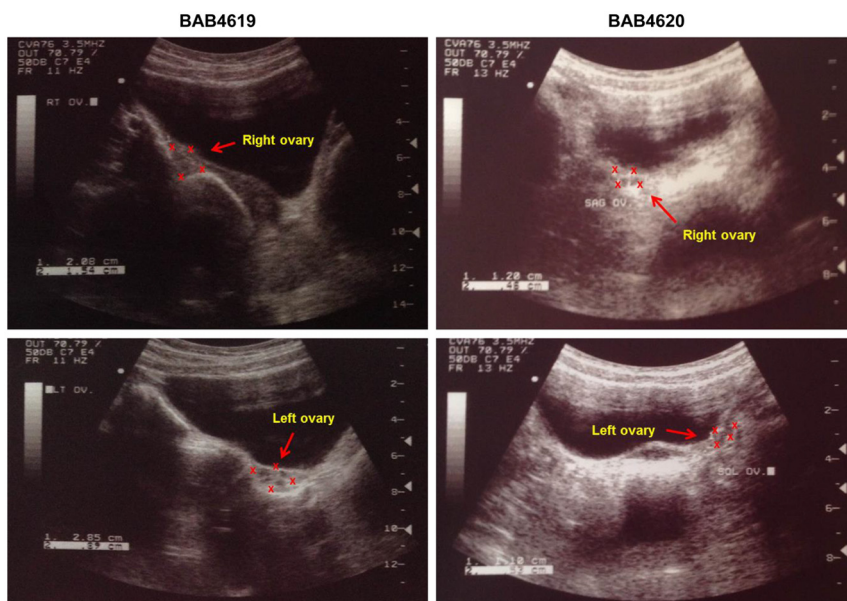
Pelvic ultrasound imaging of the patients (BAB4619 and BAB4620). The red arrows indicate the visualization of the ovaries and the red stars indicate the ovarian boundaries. These images were captured while the patients were under hormone replacement therapy. Note that the ovaries can be visualized but they are still hypoplastic (BAB4619, right: 21 × 15 mm; left: 29 × 9 mm. BAB4620, right: 12 × 5 mm; left: 11 × 5.5 mm).
